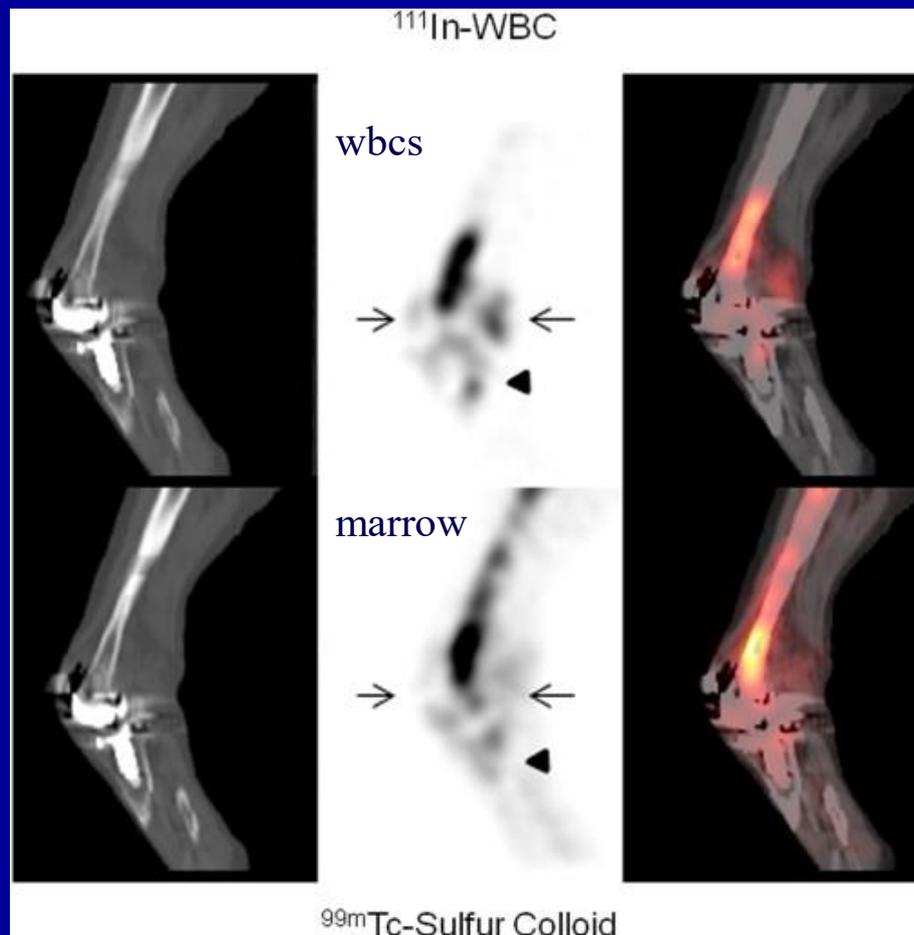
Infected right knee arthroplasty. On the sagittal images from the simultaneously acquired dual isotope SPECT CT, spatially incongruent distribution of activity on ^{111}In WBC (top) and marrow (bottom) images can be identified clearly anterior and posterior.
